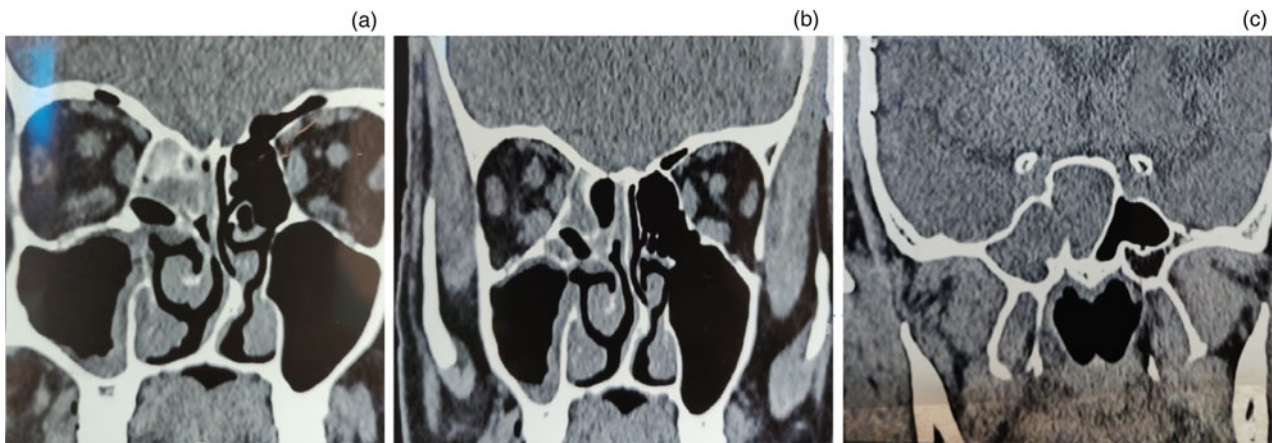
(a–c) Coronal, non-contrast computed tomography scans of the paranasal sinuses, showing involvement of the sinuses with intracranial involvement.
